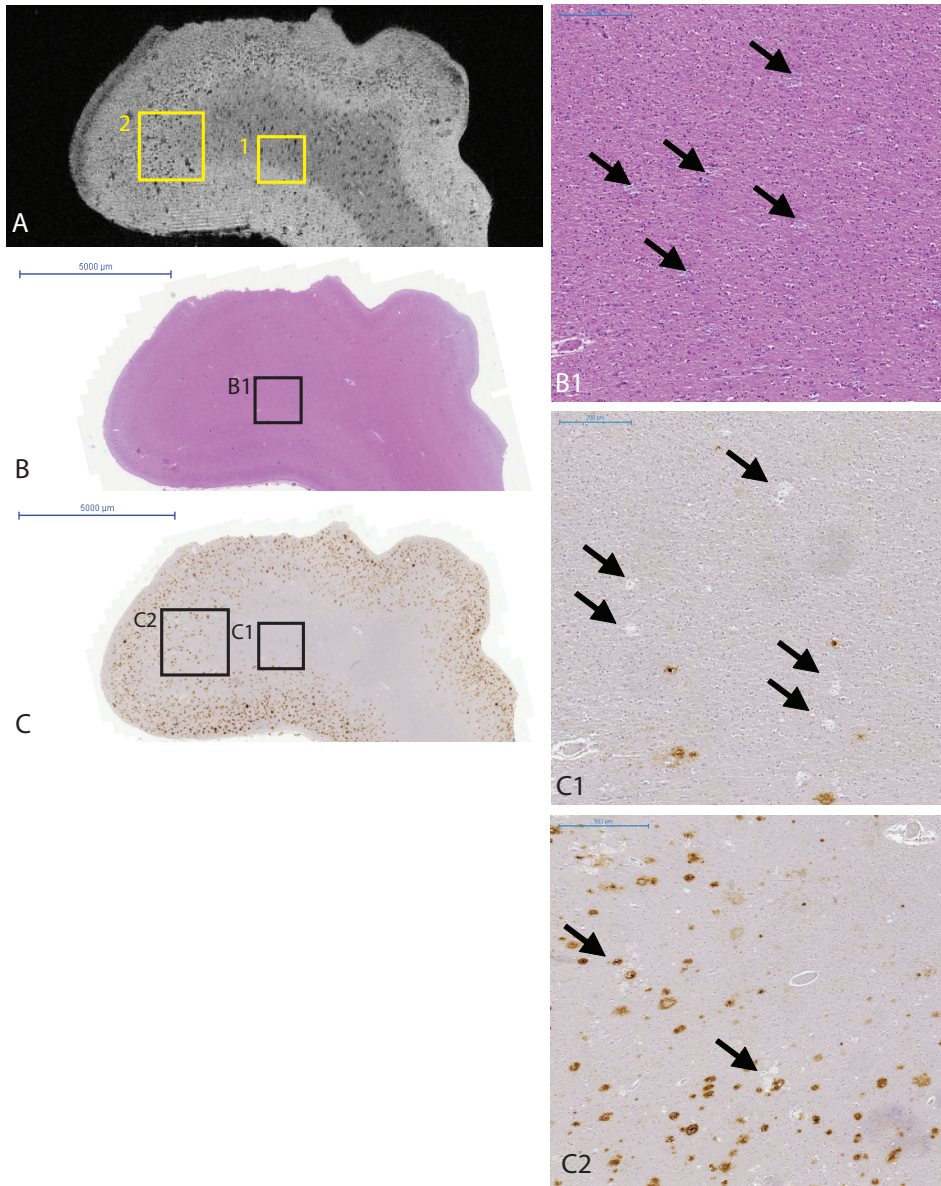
Another example of MRI hypo-intensities due to granular neuropil alterations
